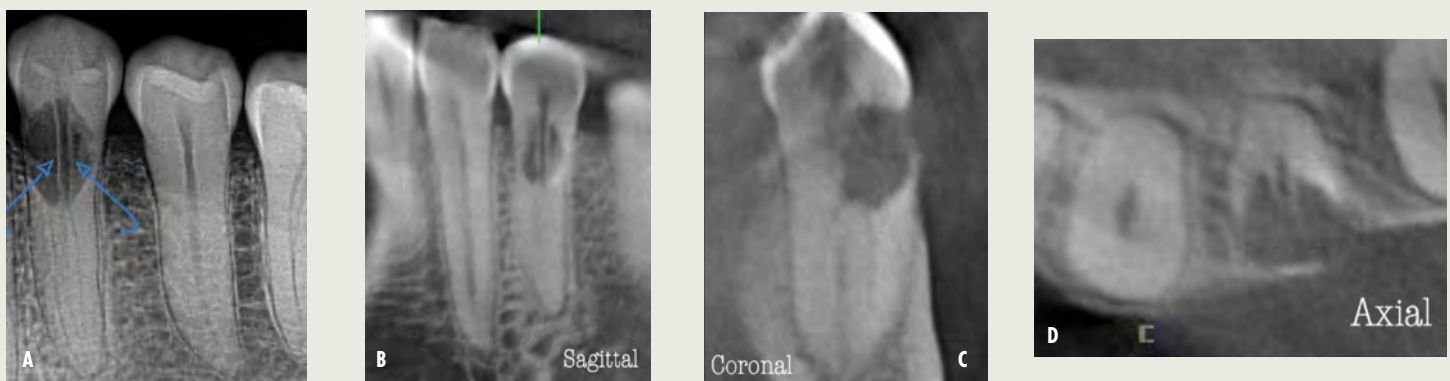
A: Periapical radiograph of tooth #21. Large resorptive defect is noted in external cervical region. Blue arrows pointing to thin layer of predentin that appears to be running through defect. Outline is what remains of root canal wall. Tooth tested vital and diagnosis of invasive cervical root resorption was made. Due to minimal remaining tooth structure, extraction was advised. B,C,D: Sagittal, coronal, axial slices show resorptive defect external to root canal.
